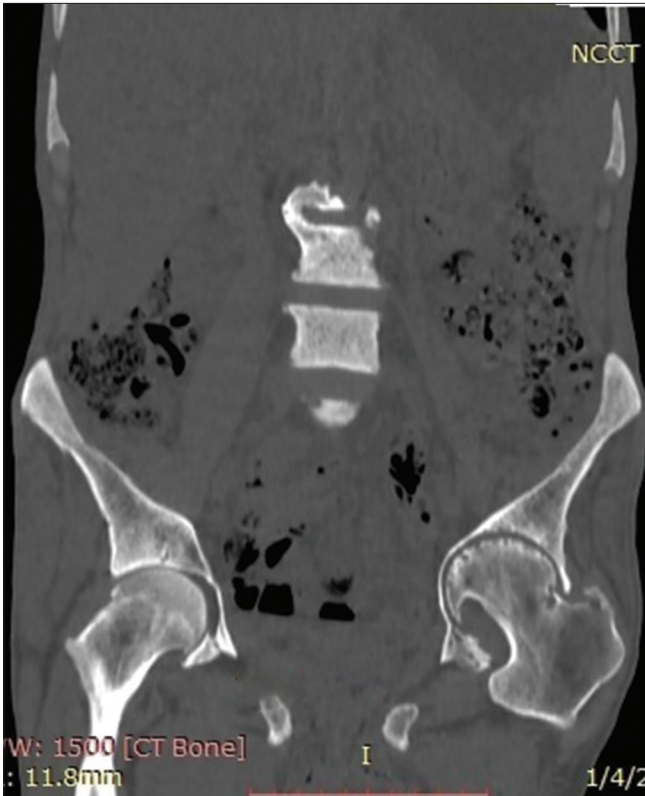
Coronal reformatted CT image showing left hip joint arthropathy with hyperostosis along the acetabular margin
